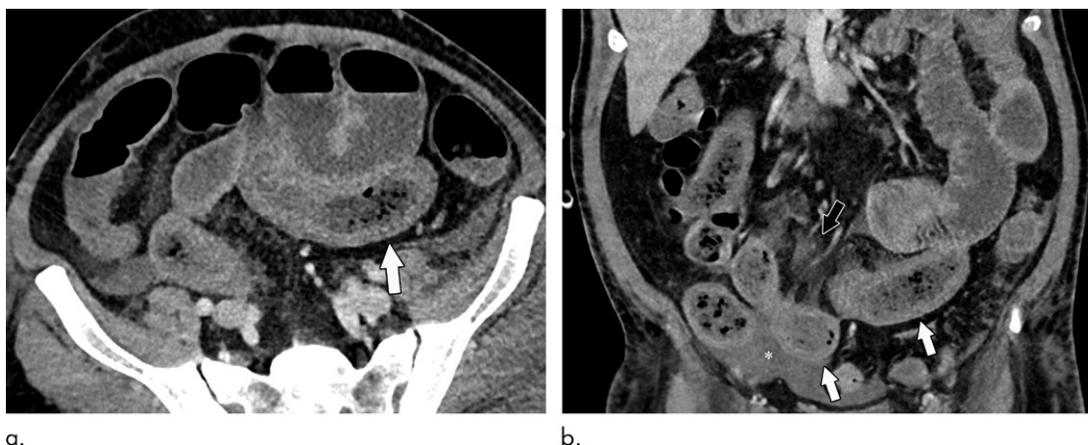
(a) Axial and (b) coronal CT images of the abdomen and pelvis with intravenous contrast material in a 57-year-old man with high clinical suspicion for bowel ischemia. There is generalized small-bowel distension and segmental thickening (white arrows), with adjacent mesenteric congestion (black arrow) and a small volume of ascites (*). Findings are nonspecific but suggestive of early ischemia or infection.
